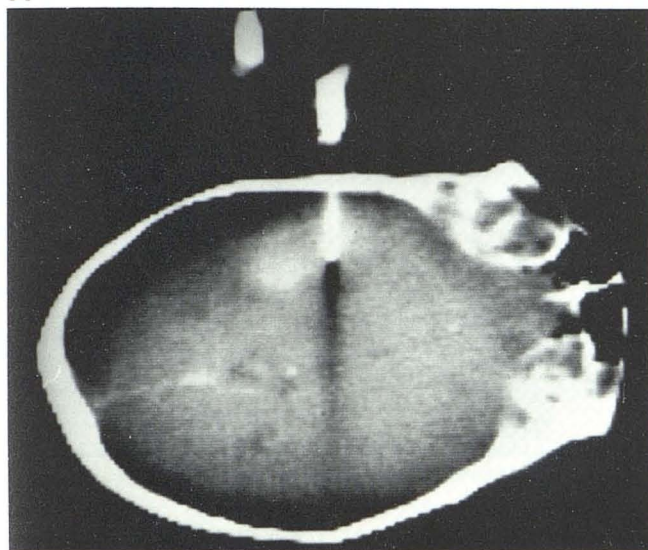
A, Intraoperative control CT scan discloses aspiration needle at bottom of abscess cavity in proper position for beginning aspiration. Linear artifact of needle depicts trajectory of needle more strongly than does air column of empty guide core. One may deliberately place needle in guide core and scan through it *before* advancing into brain to "triple-check" needle trajectory before puncture. B, Toward end of aspiration, abscess walls collapse around needle, and needle may have to be withdrawn slightly to ensure complete drainage.
